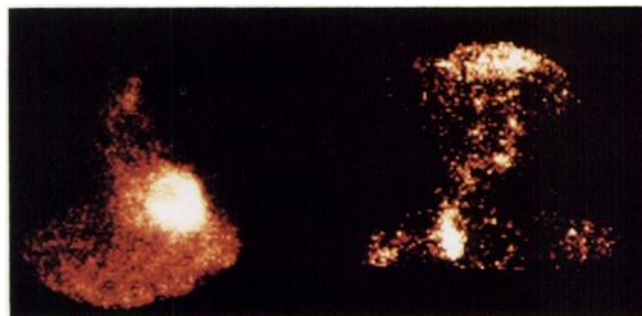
Abnormal mediastinal (left) and retroperitoneal (right) FDG uptake in a patient suspected of relapsed Hodgkin's disease (B-symptoms). CT scans of thorax and abdomen had been inconclusive (multiple nodes of approximately 1 cm). Mediastinoscopy confirmed active disease.
